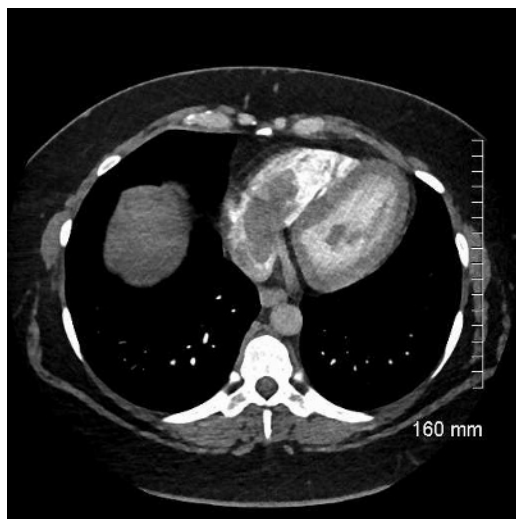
Computed tomography scan of the chest with contrast showing filling defects within the right atrium, right ventricle, and left ventricle.
